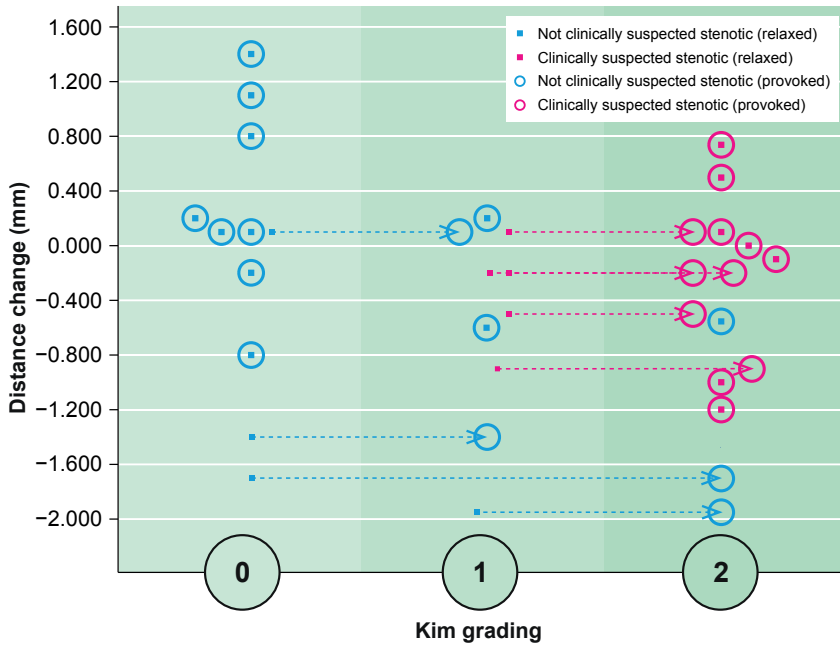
Presents the changes in the foraminal cross-distance (y-axis) mapped against the Kim classification (x-axis), which ranges from 0 to 2. The foramina categorized as suspected stenotic based on MRI findings at the time of referral are represented by red dots, while those considered non-stenotic are represented by blue dots. Post provocation, the red circles indicate the classifications of the foramina previously deemed as potentially stenotic, and the blue circles indicate the classifications of the non-stenotic foramina.
